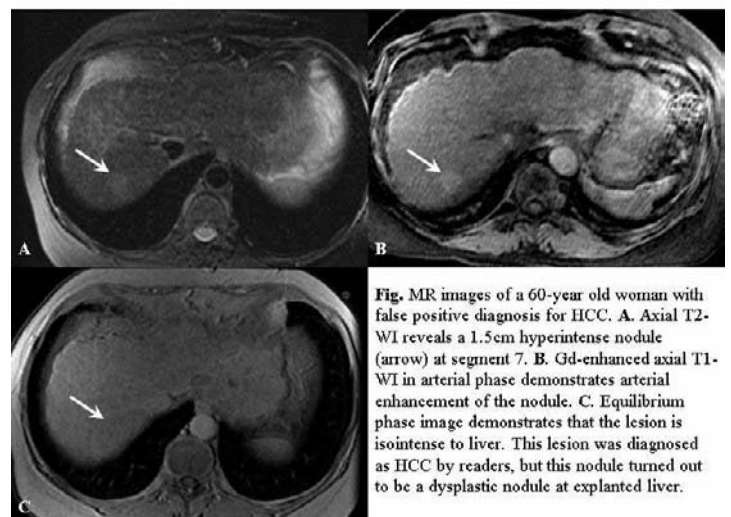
MR images of a 60-year old woman with false positive diagnosis for HCC. A. Axial T2-WI reveals a 1.5cm hyperintense nodule (arrow) at segment 7. B. Gd-enhanced axial T1-WI in arterial phase demonstrates arterial enhancement of the nodule. C. Equilibrium phase image demonstrates that the lesion is isointense to liver. This lesion was diagnosed as HCC by readers, but this nodule turned out to be a dysplastic nodule at explanted liver.
